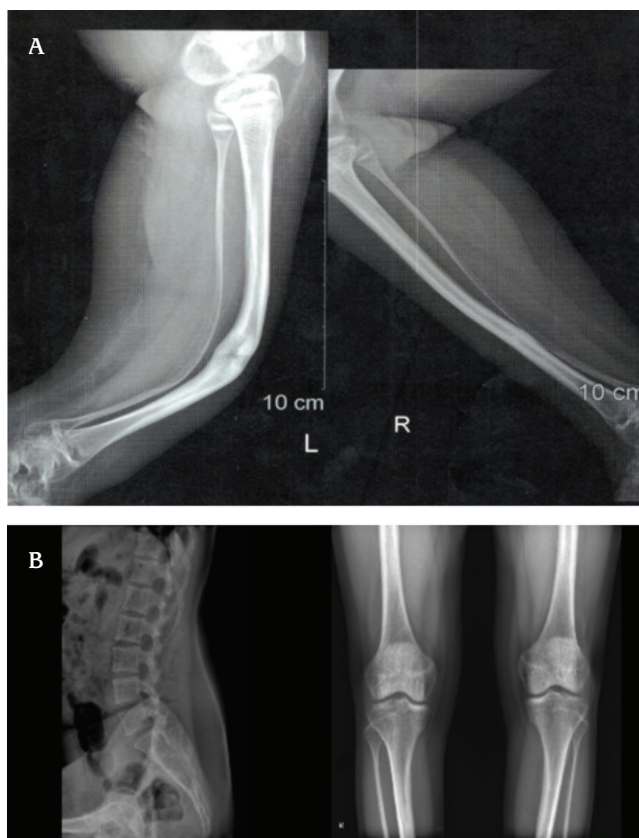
A) X-ray radiography of the patient's tibia and fibula, B) X-ray radiography of the patient's lumbar spine and knees
